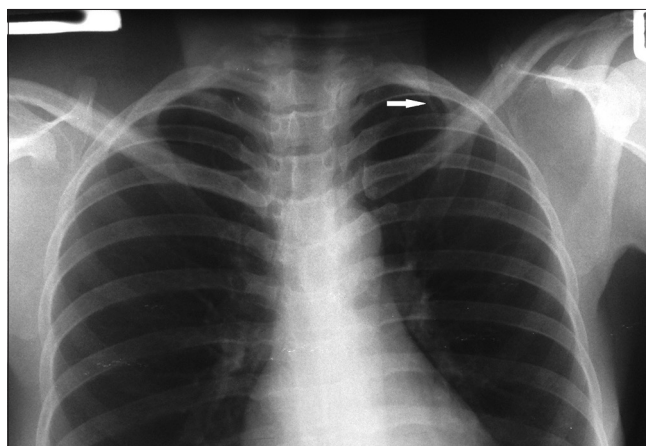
PA chest radiograph showing a left-sided cervical rib (white arrow)
